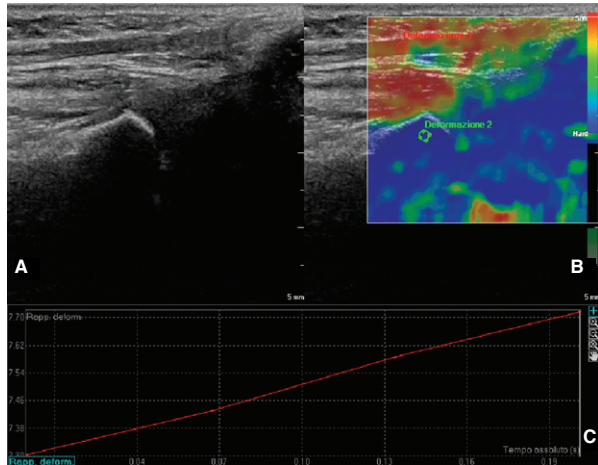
(A) Longitudinal B-mode ultrasound scan and superimposed (B) sonoelastogram of a physiologic distal third of the Achilles tendon. The elastography was evaluated positioning two circular ROIs, of about 3 mm in diameter, respectively on the Achilles tendon and on the bone tissue. (C) The Strain index and the ratio was then calculated between the Achilles tendon and the bone tissue.
